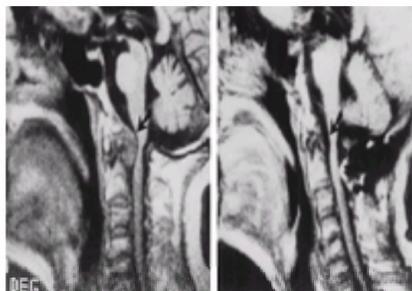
Preoperative MRI (left) and 4 months postoperative MRI (right) after successful surgical fusion. Arrows indicate periodontoid pannus.
